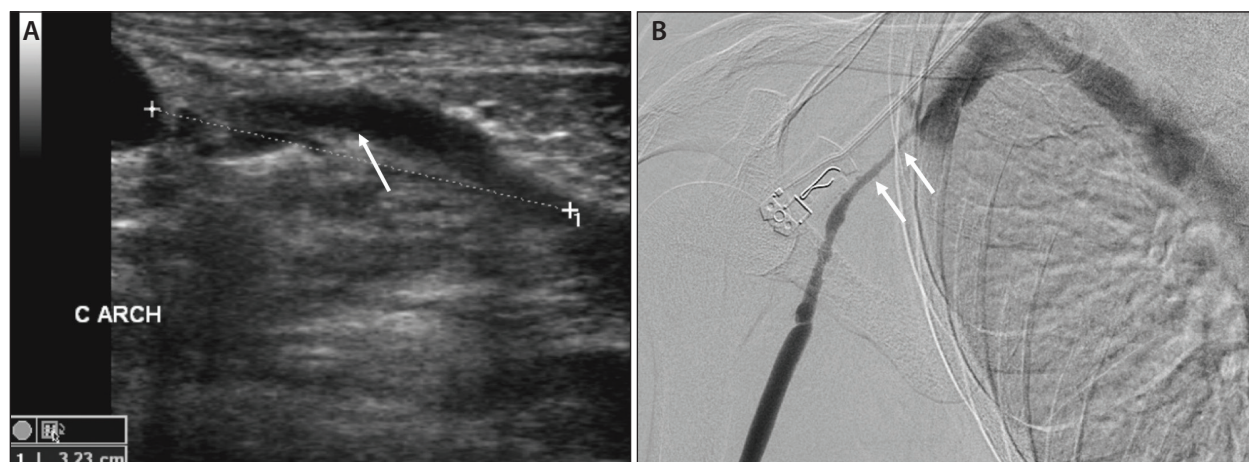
B-mode ultrasound image demonstrating a cephalic arch stenosis and a diameter reduction of the vein and less neointimal hyperplasia (white arrow) as compared with Figure 1 (A). Fistulagram for the same patient demonstrating a cephalic arch stenosis (white arrows) prior to fistulaplasty (B).
